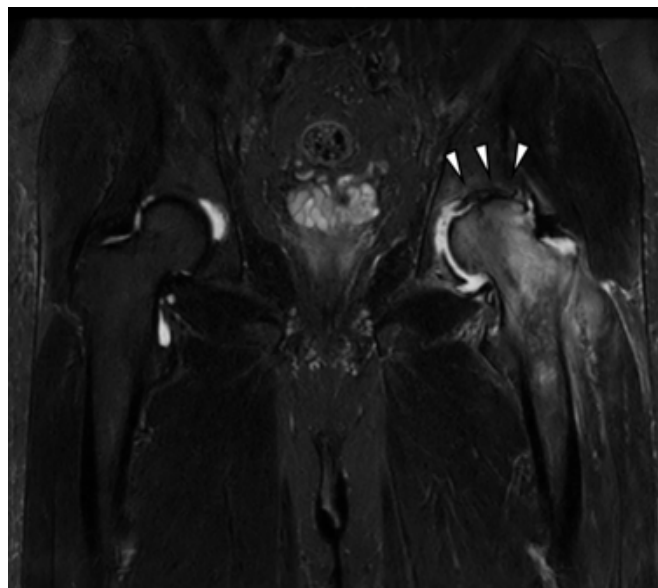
Magnetic resonance imaging obtained at the initial visit demonstrating collapse of the femoral head and fluid collection around the hip joint (arrowhead).
